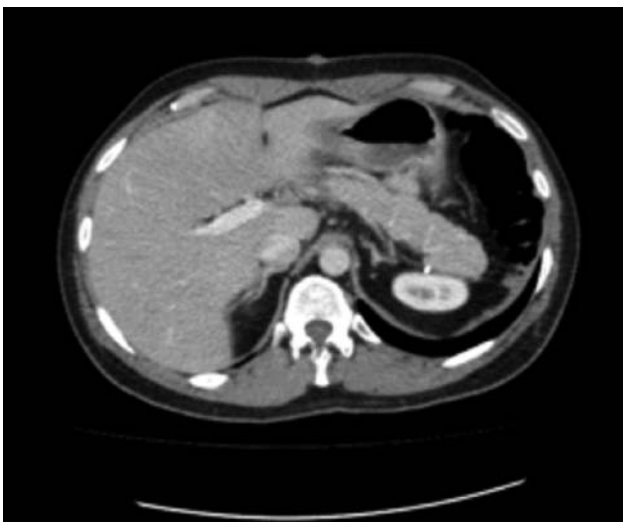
Representative three-month post-operative CT scan images demonstrating complete cytoreduction (CC-1) without evidence of disease.
